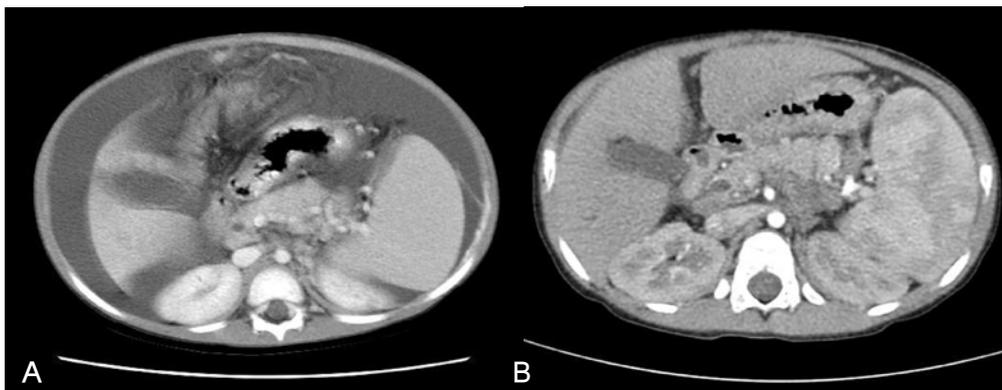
Abdominal CT findings before (A) and after treatment (B). Fig 2A shows massive ascites without other intra-abdominal abnormality. (B) shows a reduced amount of ascites and a patent splenorenal shunt.
